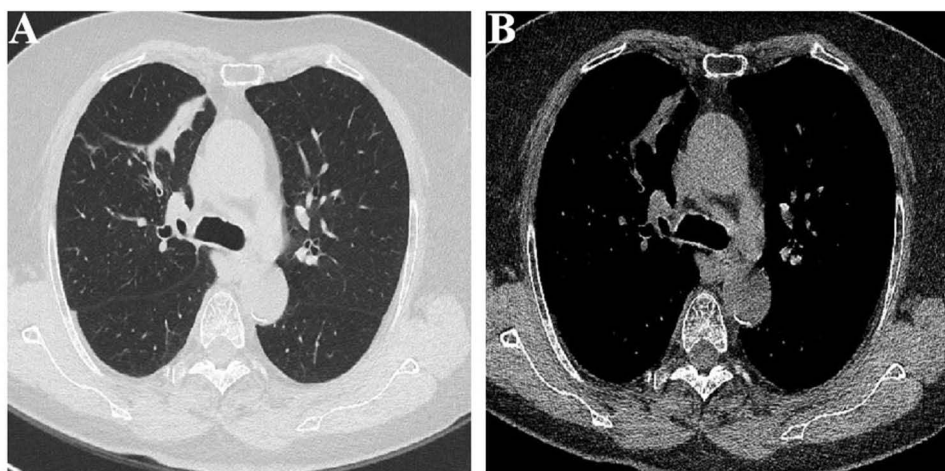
Segmental atelectasis of the right upper lung secondary to glandular papilloma of the right upper bronchus. (A) CT plain image in lung window; (B) CT plain image in soft-tissue window.
